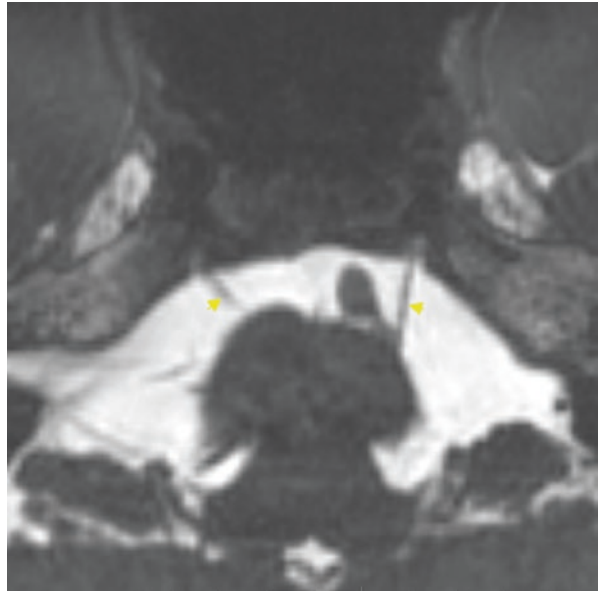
3-T CISS MRI brain: oblique-axial view of pontomedullary junction showing normal VIth nerves (arrowheads) exiting the pontomedullary junction
